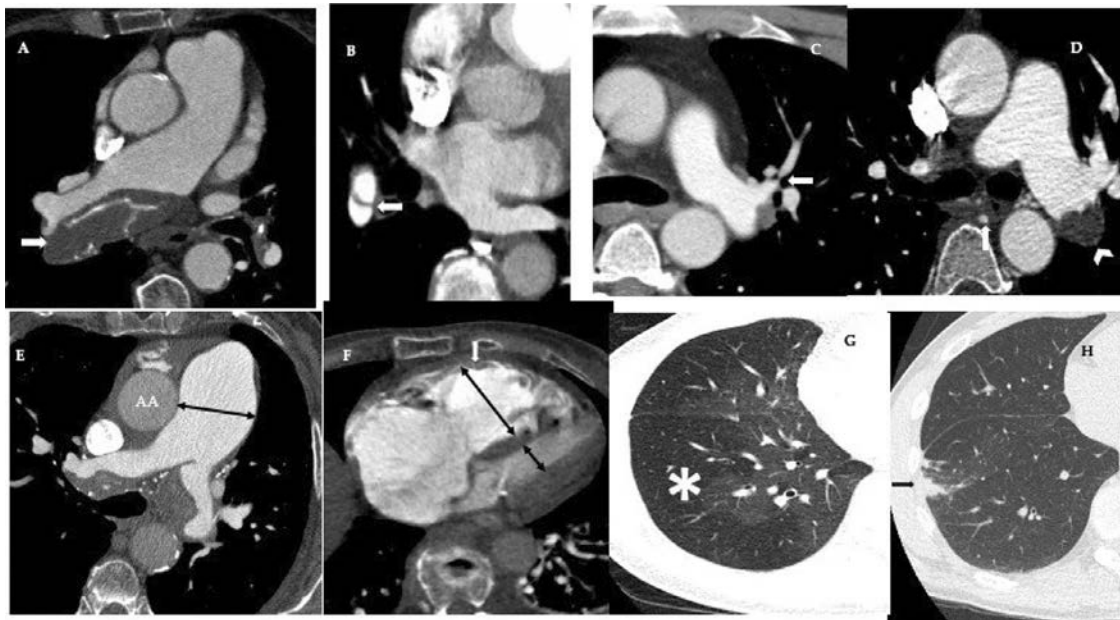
Signs of CTEPH on CTPA. (A) Eccentric calcific thrombus (arrow) in distal right main pulmonary artery. (B) Magnified view of the right lower lobe demonstrates a slit (arrow) in the segmental artery. Multiple slits are termed a web. (C) Stenosis (arrow) in left upper lobe artery (D) Dilated and tortuous bronchial artery collaterals (arrow) & occlusive thrombus (chevron) in the left interlobar artery. (E) Dilatation of the main pulmonary artery measuring 37 mm, larger than the accompanying ascending aorta (AA). (F) Dilated right ventricle (long double-ended arrow) relative to the left ventricle (short double-ended arrow). Also note hypertrophy of the right ventricular wall (white arrow). (G) Mosaic attenuation. The hypodense lung (*) corresponds to areas of decreased perfusion. (H) Curvilinear subpleural band opacities (arrow) corresponding to chronic pulmonary infarct. CTEPH, Chronic thromboembolic pulmonary hypertension; CTPA, Computed tomography pulmonary angiography.
